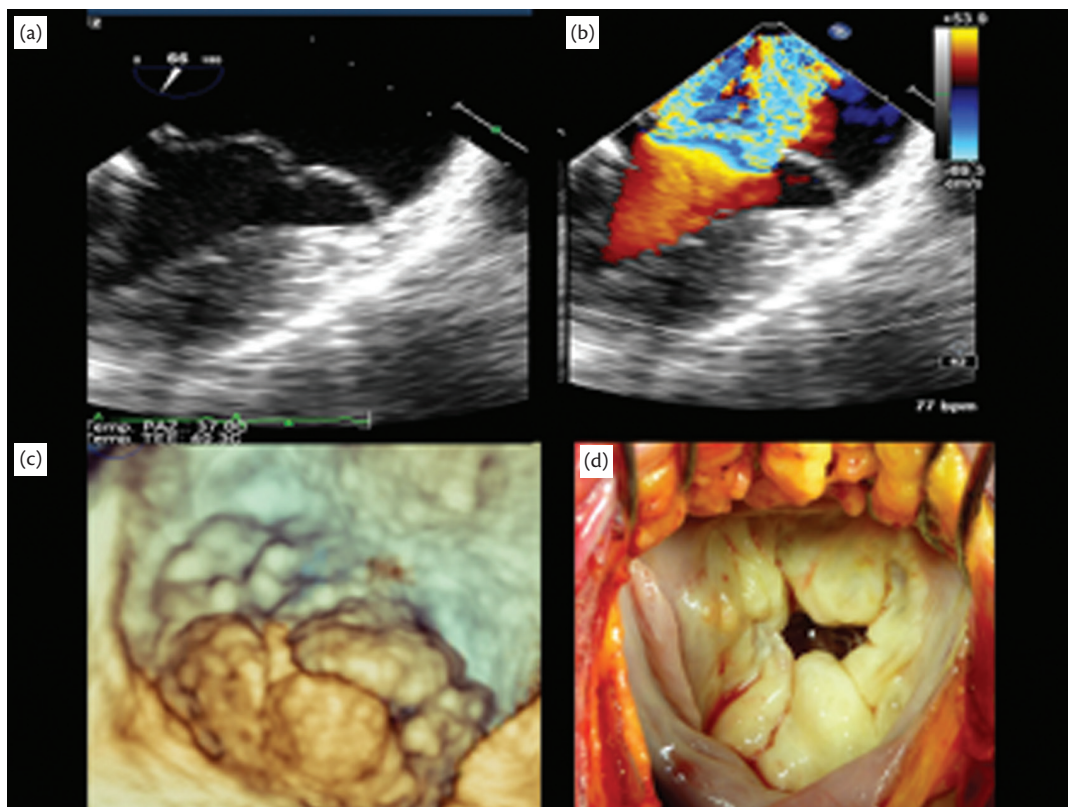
Myxomatous mitral valve with bileaflet prolapse and severe valve regurgitation. (a) Two-dimensional TOE. (b) Colour Doppler TOE. (c) Real-time three-dimensional TOE. (d) Intraoperative finding.
